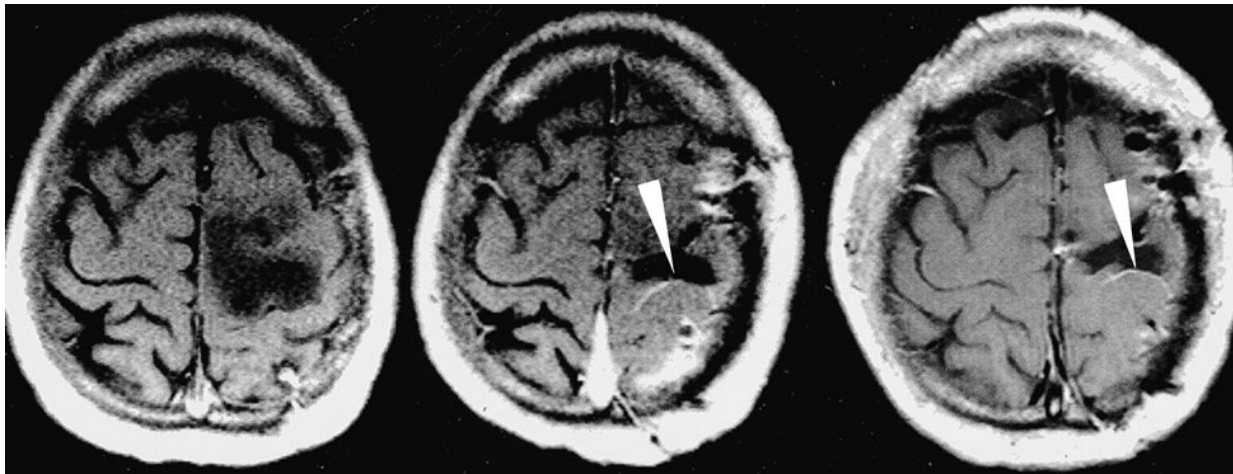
Surgically induced meningeal enhancement. The preoperative MR image (*left*) (674/20/2) does not show contrast enhancement of the pial surface in the central sulcus, which clearly enhances on the intraoperative MR examination (*middle, arrow*) (532/15/3). This enhancement persists on the early postoperative MR examination (*right, arrow*) (674/20/2).
